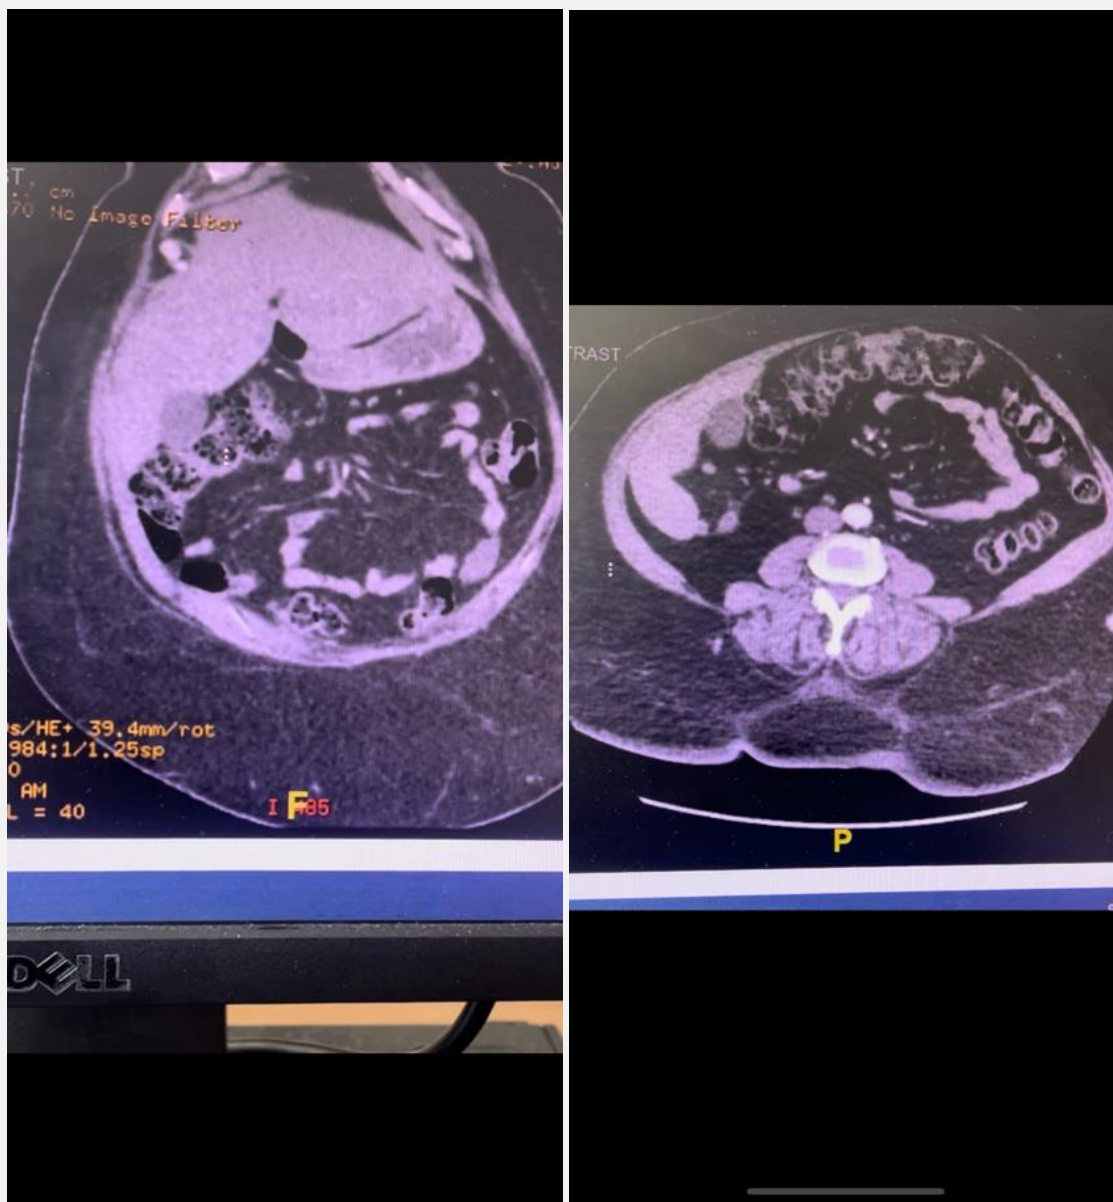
CT scan showing sub-hepatic appendix
